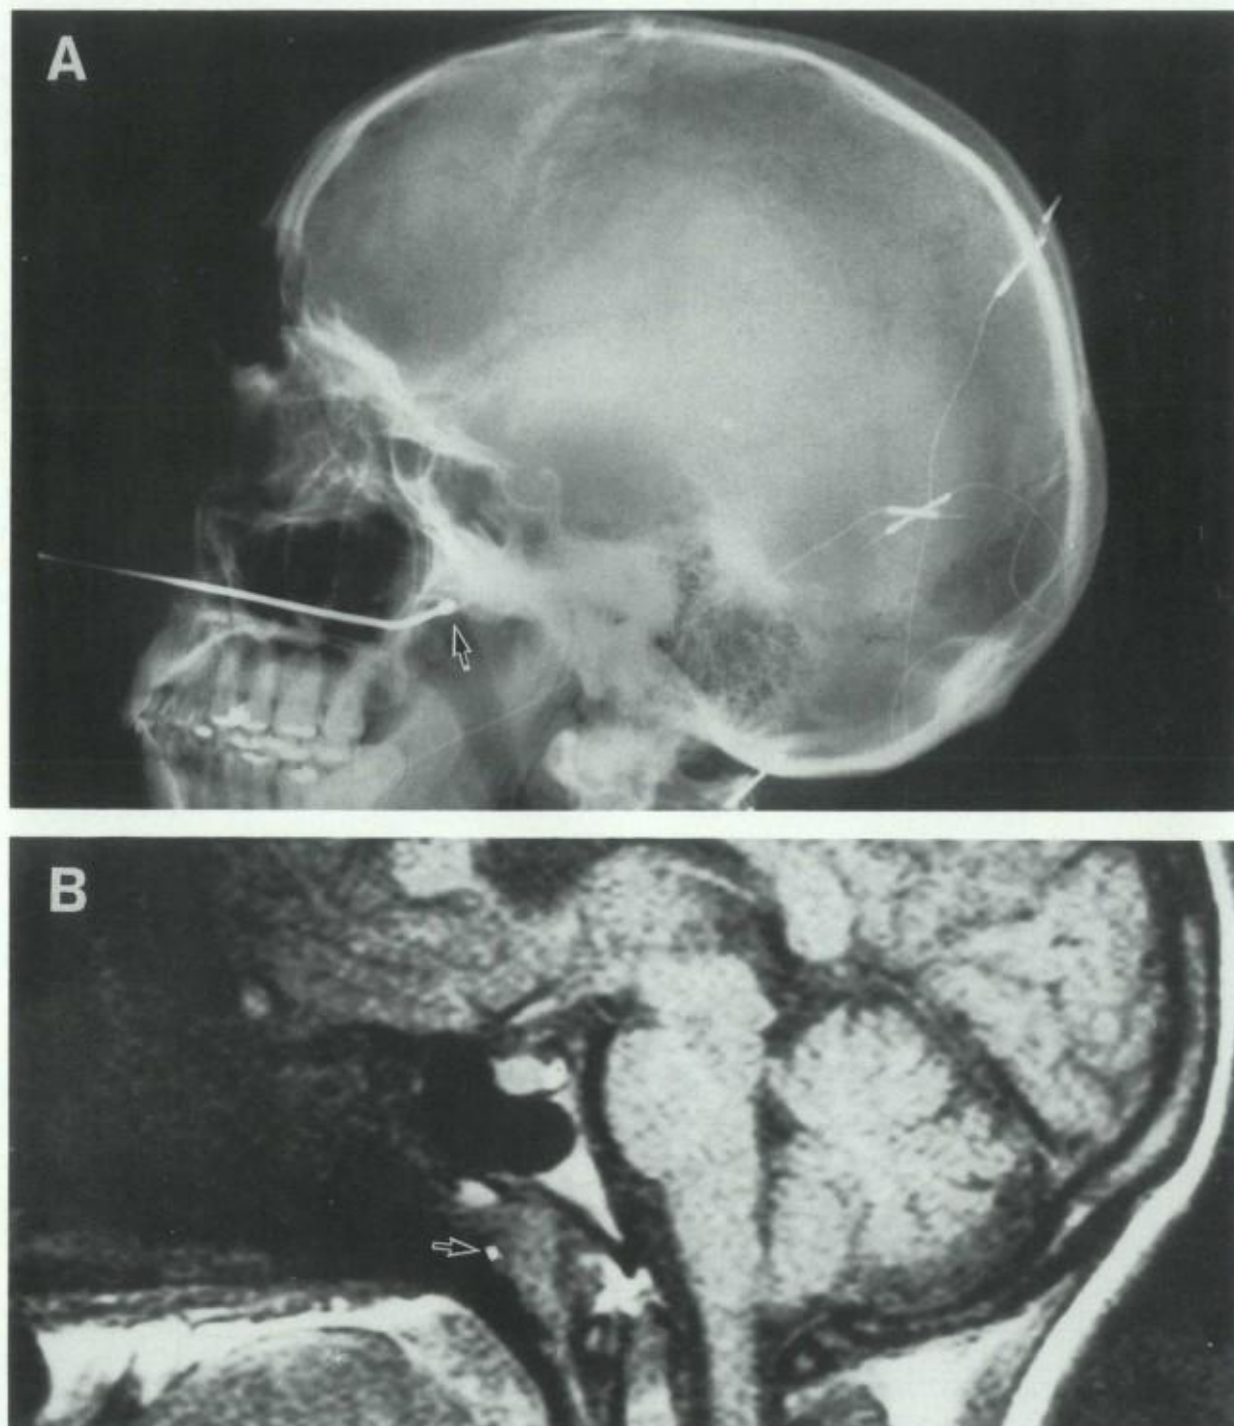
Nasopharyngeal electrode in position against the upper posterior wall of the pharynx in X-ray (A) and magnetic resonance imaging (MRI) (B).
